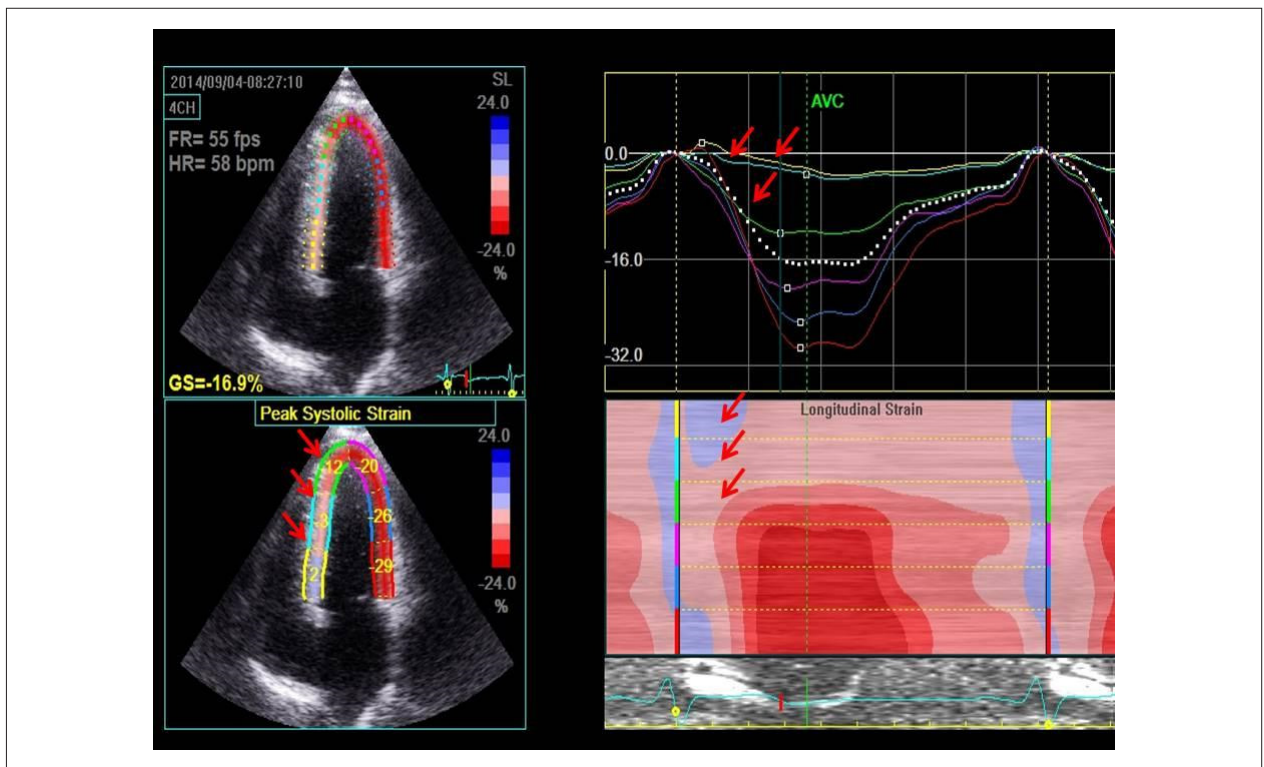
Representation of longitudinal strain assessment in a patient with HCM. A reduction in longitudinal strain values is observed in the hypertrophic (basal, middle, and apical) segments of the septal wall (arrows) in the apical four-chamber view. Source: Authors' personal archive.
